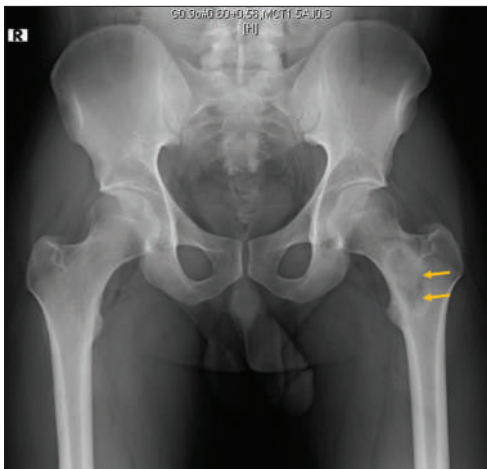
Plain radiograph of pelvis
